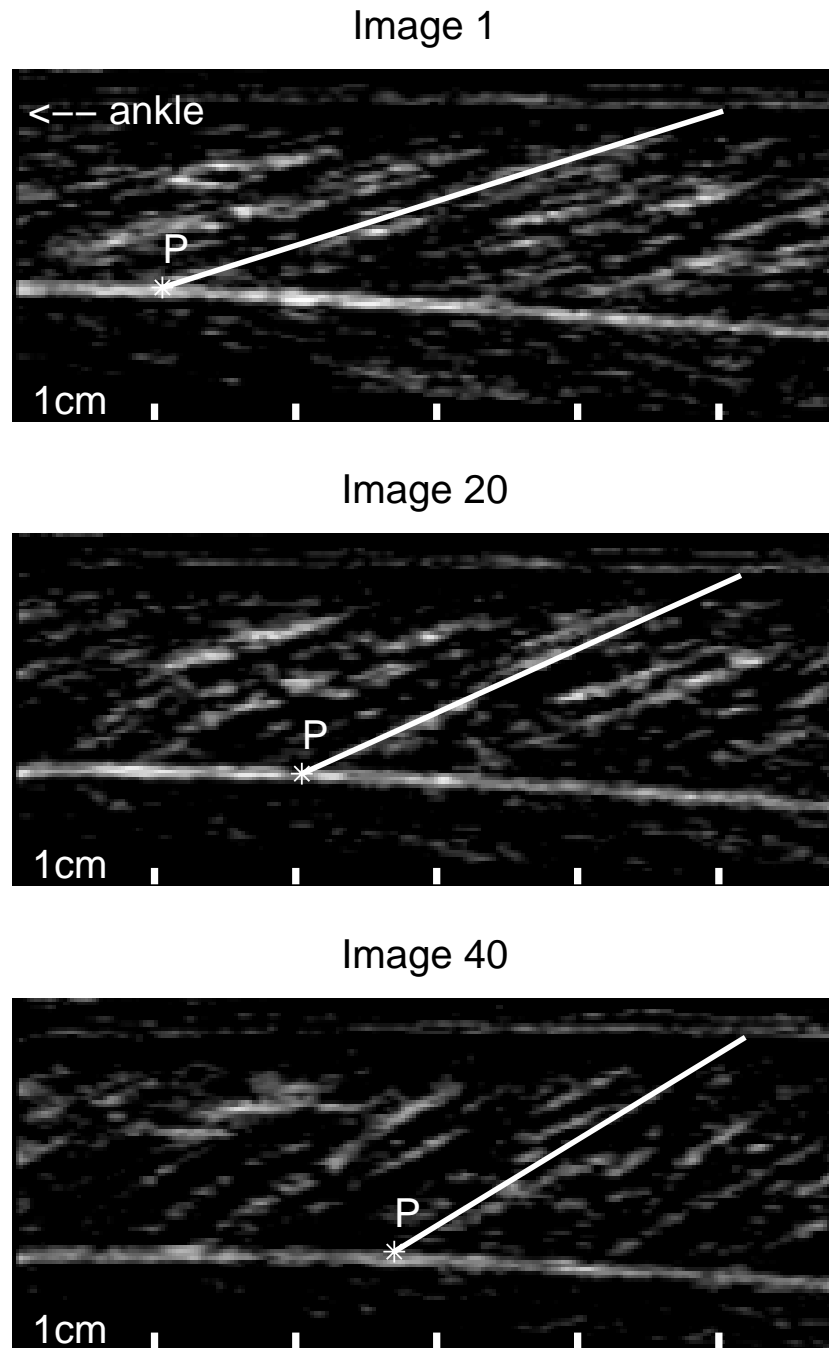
Series elastic strain measured from 40 ultrasound images, shown are the images of subject 4.*
